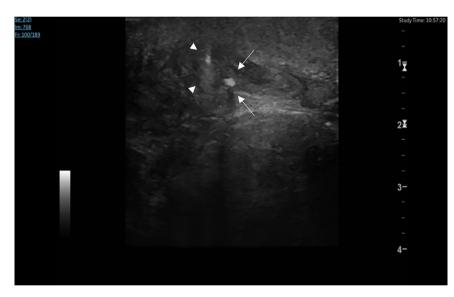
Ultrasound image of the parotid salivary gland in Case 1 during botulinum toxin A injection. A hyperechoic area can be seen (arrows) representing the injected botulinum toxin type A. The acoustic shadow (arrowheads) belonging to the needle can also be observed.
